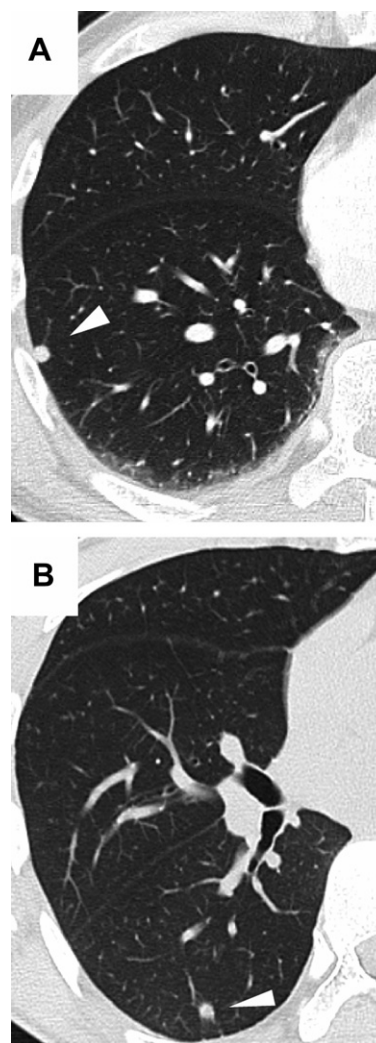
(A) Chest computed tomography revealed a small, round nodule in the lower lobe (case 2). (B) An angular and partly spiculated nodule shown in the lower lobe (case 5).
